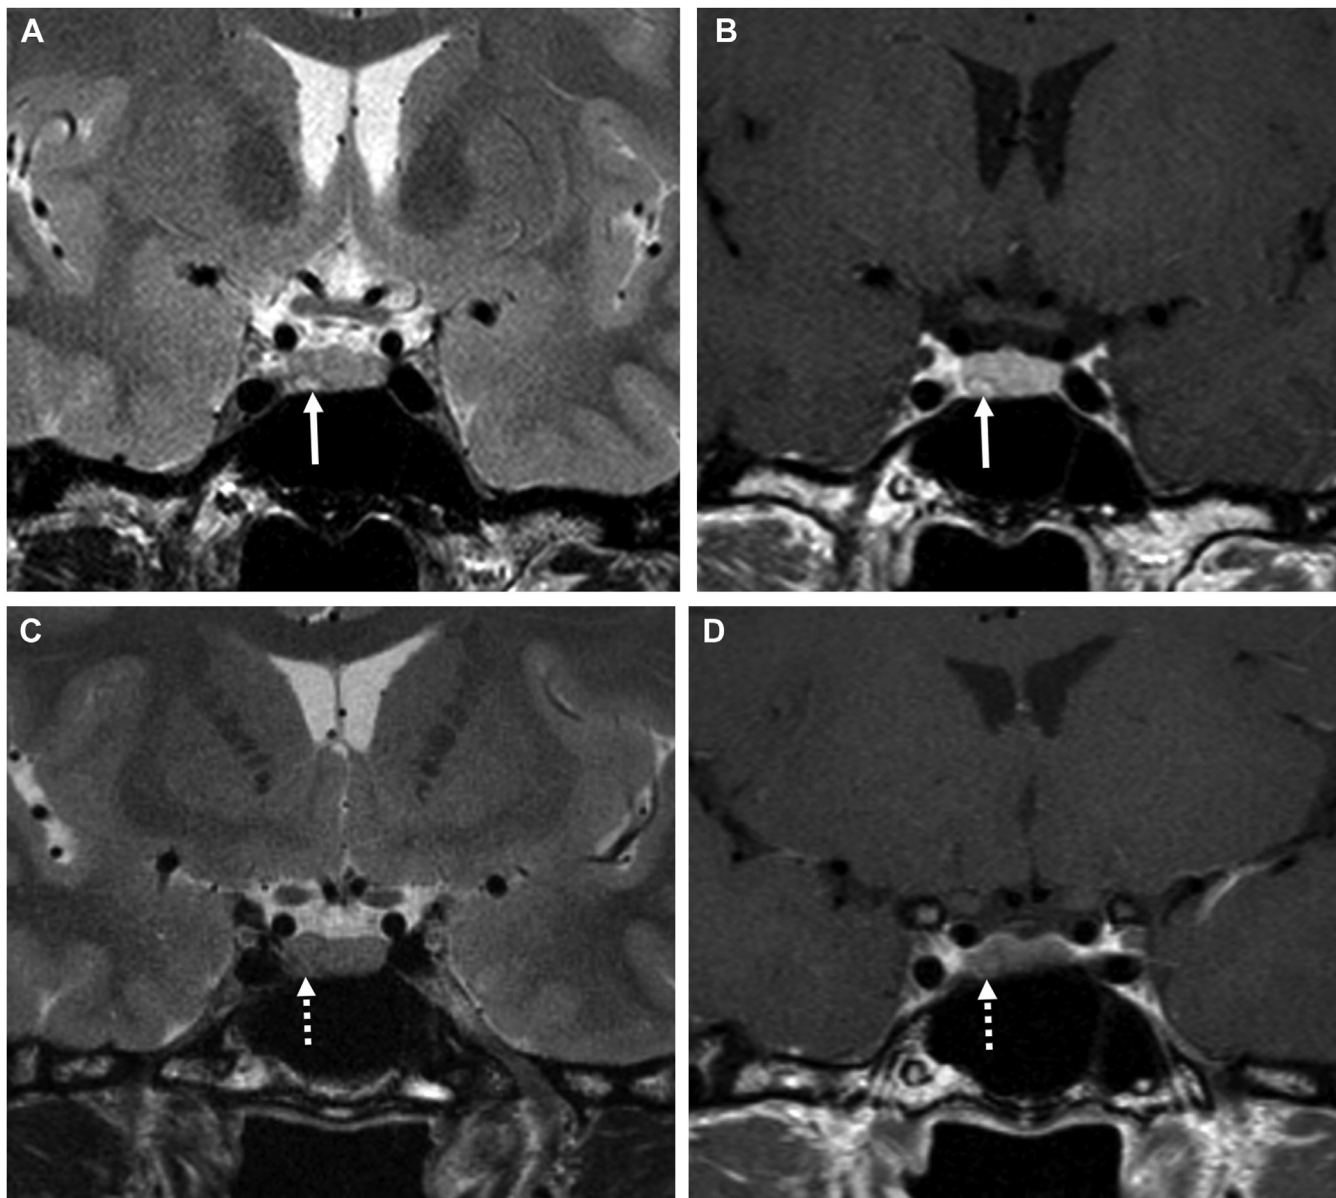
MRI Sella. A and B: MRI sella from 2011 showing small lesion in the *Right* inferior aspect of the pituitary gland that is (A) hyperintense on T2 weighted image (T2WI) and (B) hyperenhancing on post-contrast T1WI. C and D: MRI sella from 2020 showed evolution in signal within the lesion, now mostly (C) isointense compared to the rest of the pituitary gland on T2WI and (D) post-contrast T1WI.
